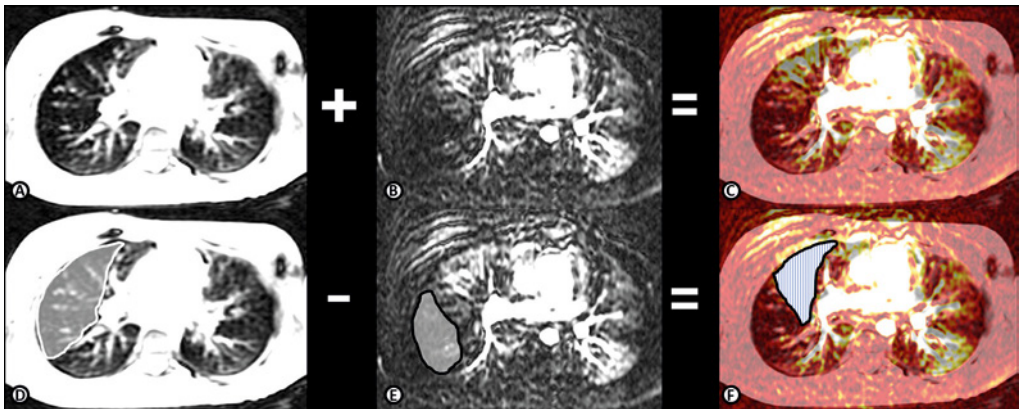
Comparison between MRI_{TA} and $CEMRI_{HP}$ by an observer using the PROPER scoring system. (A and D) end-expiratory axial 2D Steady-State Free Precession (SSFP) proton-MRI, (B and E) axial end-expiratory reformat 3D Spoiled Gradient Echo (SPGR) with TRICKS contrast-enhanced MRI (CEMRI), and C and F) Fusion Image CEMRI overlaid on MRI. Note that area trapped air in right upper lobe in image D (white line area) and area of hypoperfusion in image E (black line area). When compared on fusion image F, trapped air is larger than the hypoperfusion (line pattern area in F). Hence, for this lobe a score of -1 is given.
